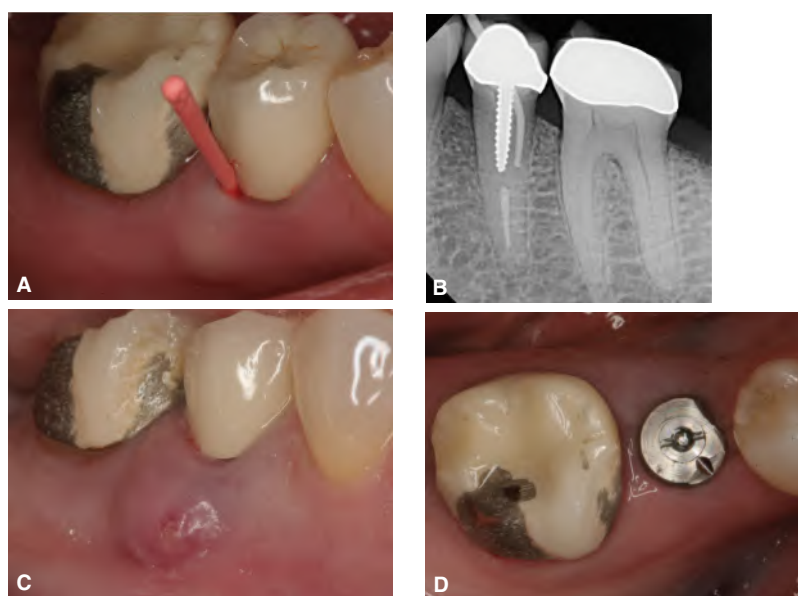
Complications of certain defects along the root may have similar clinical appearance of primary endodontic disease with secondary periodontal involvement. A. Patient presented with a localized deep pocket (traced with a gutta-percha cone) associated with an endodontically treated mandibular second premolar. B. Periapical radiograph showing the gutta-percha cone pointing to an area of the root associated with a screw post. C. Subsequent abscess formation on the buccal aspect of the tooth caused loss of the buccal plate. D. Surgical exploration confirmed the presence of a vertical root fracture and the tooth was extracted and replaced by an implant. (Courtesy of Dr. Ziv Simon, Beverly Hills, CA, U.S.A.)
